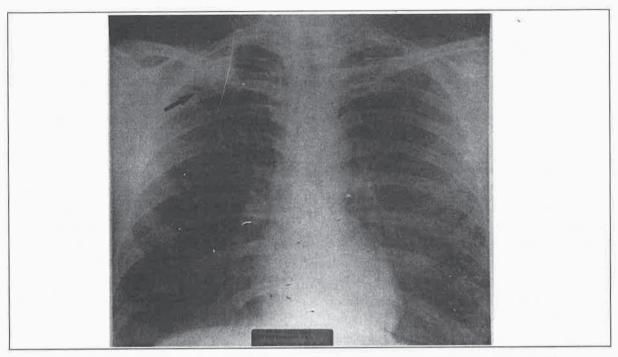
Chest X-ray showing a homogenous mass density (arrow) in the right upper lung field
